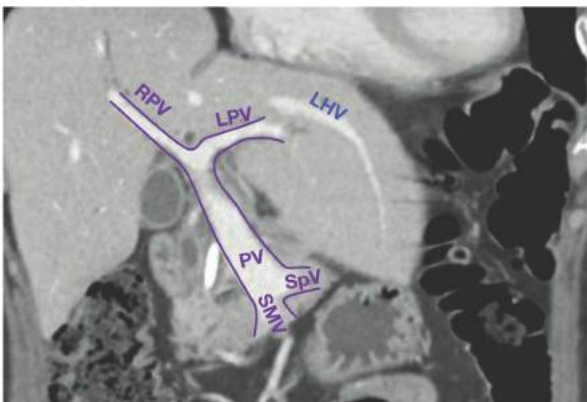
• Coronal CT demonstrating the branching of the left (LPV) and right (RPV) portal veins off the main portal vein (PV), which originates at the confluence of the superior mesenteric vein (SMV) and the splenic vein (SpV). Note the acute angle made by the LPV as it enters the liver. Also shown is the left hepatic vein (LHV).
